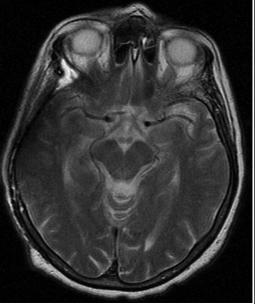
Postoperative MRI scan
